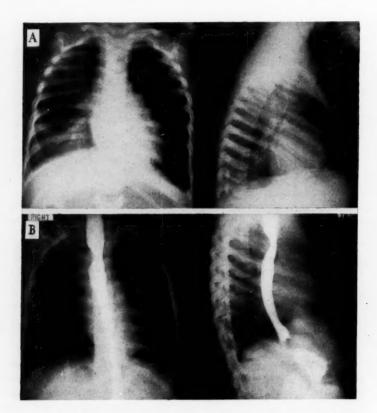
Case 7.—(A) Chest x-rays of patient at the age of two years showing no apparent abnormality of the heart or great vessels. Infiltrate at right base represents one of repeated attacks of pneumonia. (B) Esophagrams showing posterior and lateral rounded defects at the level of the arch of the aorta.
